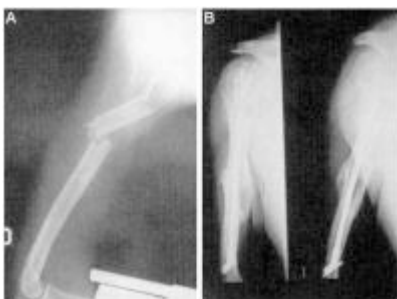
Preoperative (A) and follow-up radiographs (B; at 15 weeks) of a patient treated with IEN (G.R.; [Table 2](#)).
